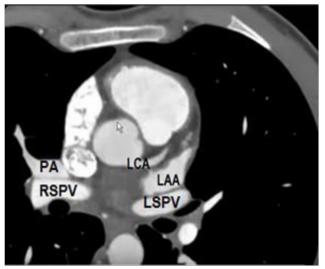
Computed tomography of the heart. The left atrial appendage can be visualized on the left side of LA. It is an anterior structure. The vein close to LAA is the LSPV and the vein on the right side is the RSPV. Inferior veins cannot be seen in the same plane with the LAA. The right pulmonary artery (PA) is close to RSPV.
